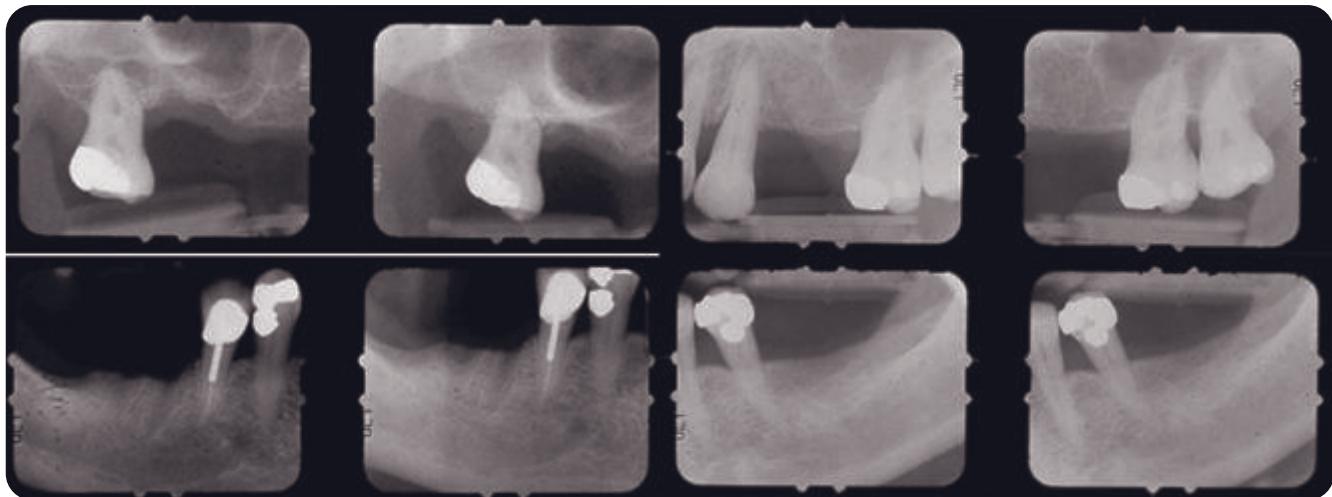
Preoperative posterior radiographs. The periodontium, although reduced, is maintainably healthy. There is generalized grade 1 mobility. Note sinus anatomy upper right.
